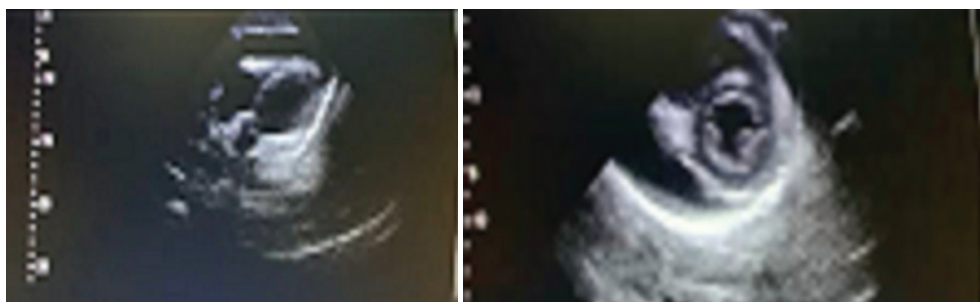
Echocardiography with evidence of a pericardial effusion in 17-year-old girl with hypothyroidism
